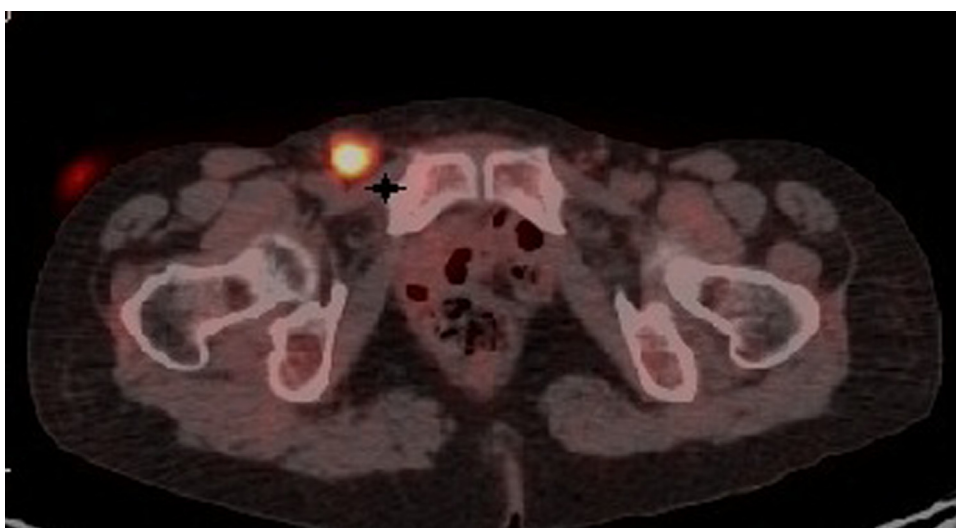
FDG PET/CT with hypermetabolic right inguinal lymph node (asterisk).
